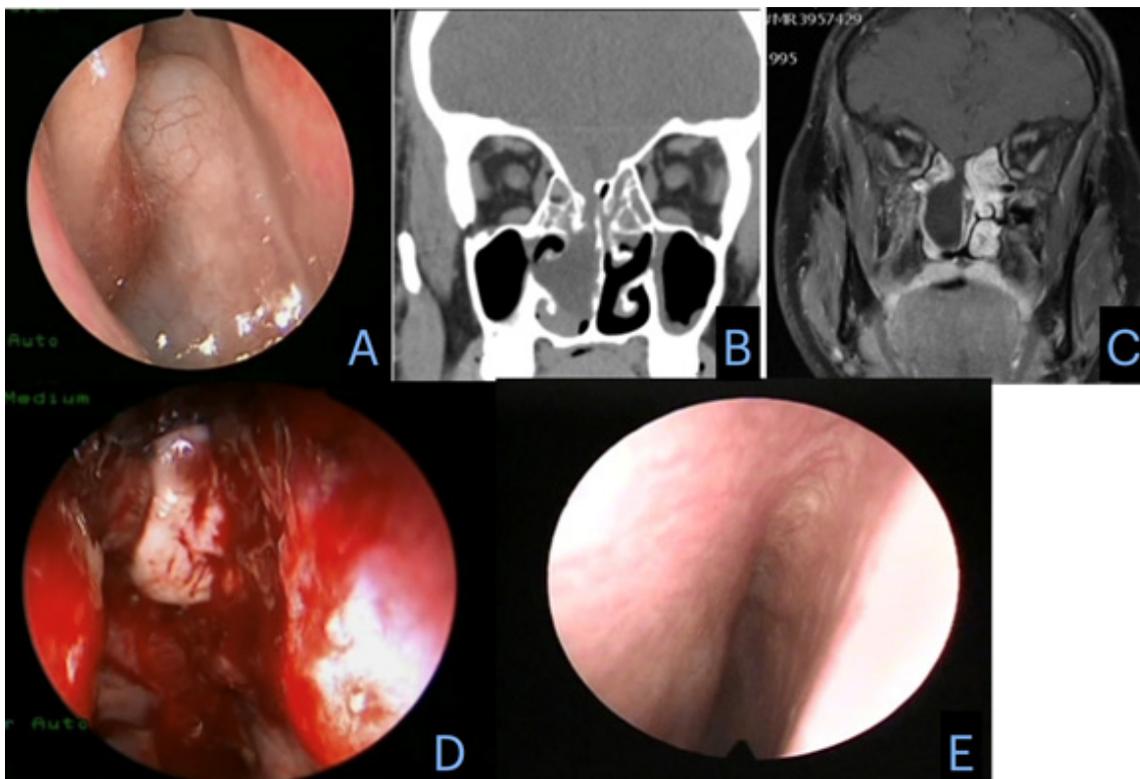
(A): Nasal endoscope shows meningocele mass medial to middle turbinate in the right nasal cavity, (B): A CT sinuses show a large meningocele filling nasal cavity with cribriform plate of ethmoid defect, (C): MRI sinuses meningocele filling nasal cavity with cribriform plate of ethmoid origin, (D) Intraoperative view skull base defect closure with septal mucosa onlay free graft, (E): Postoperative endoscopic view showing the healed skull base defect.
